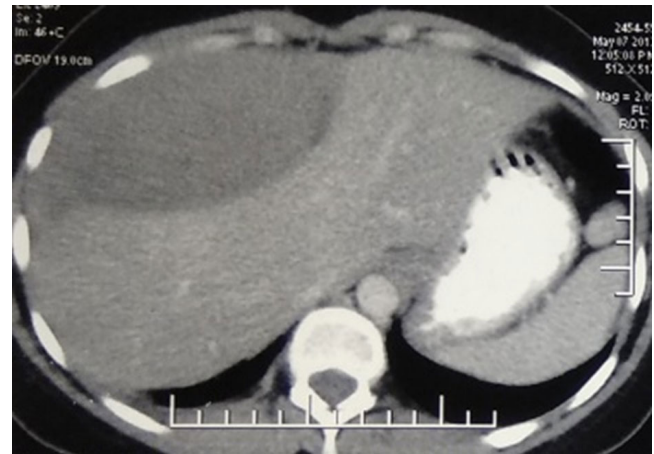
Axial image of computed tomography chest at level of liver
